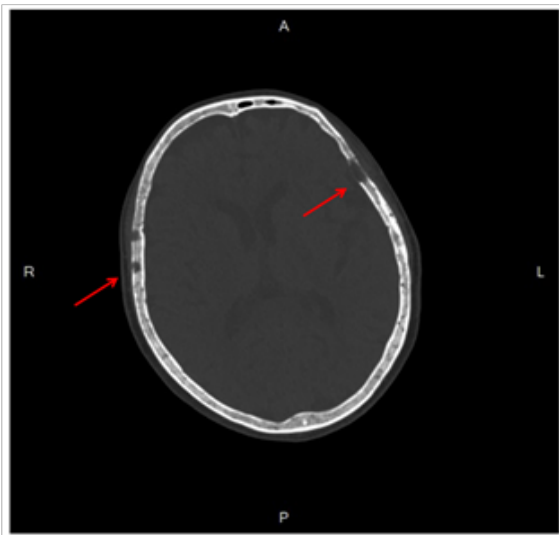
Computed Tomography (CT) scan of the patient's skull revealed multiple punched-out appearance (arrows).
